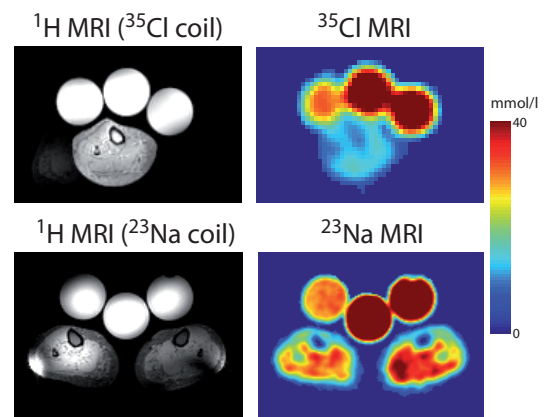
^{35}Cl and ^{23}Na MRI of a patient with hypokalemic periodic paralysis. For comparison ^1H MRI data is presented. ^{35}Cl MRI: Only the right lower leg was examined. The presented image ($\text{TE} = 0.35$ ms) already exhibits T_2^* weighting. The apparent Cl^- concentration is 13 ± 2 mmol/l. Bi-exponential fitting revealed a Cl^- concentration of 18 ± 2 mmol/l. ^{23}Na MRI: The average Na^+ concentration of the right lower leg is 26.6 ± 0.5 mmol/l.
